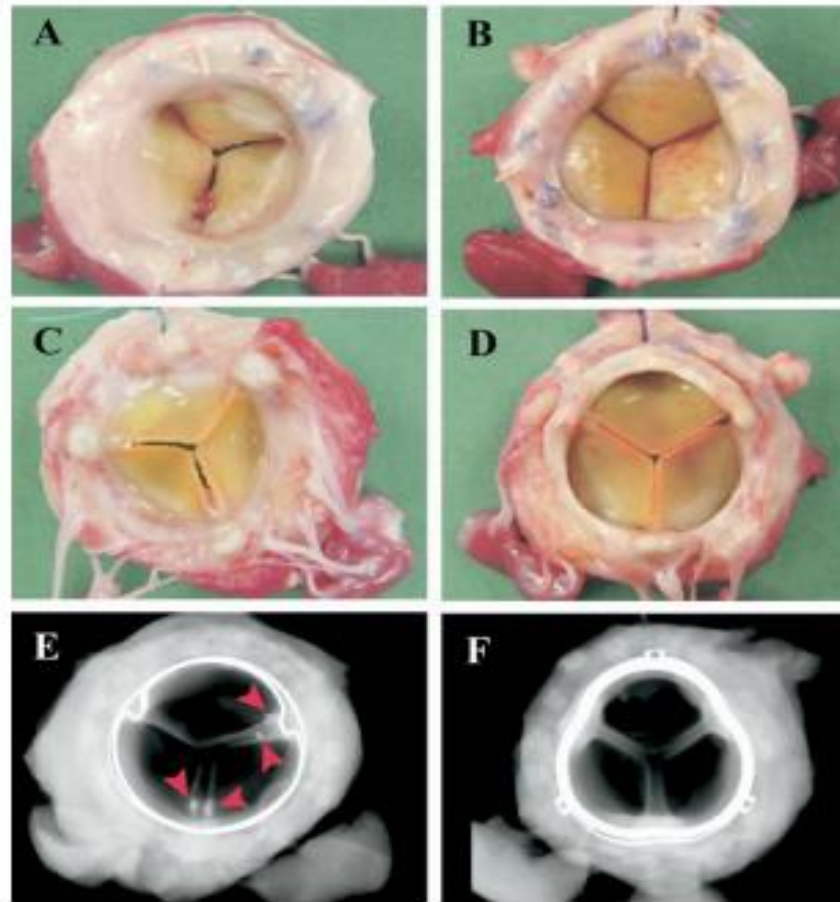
Typical examples of valves explanted after five months in mitral position: gross examination of the explants and their Faxitron (Wheeling, IL) X-ray pictures. Left panels (A, C, E): explanted Perimount valve (Edwards Lifesciences) (atrial side, ventricular side, and X-ray). Right panels (B, D, F) show an explanted Trilogy valve (Arbor Surgical Technologies Inc) (atrial side, ventricular side, and X-ray). Note the clear commissural calcifications in two commissures of the Perimount (arrowheads).
